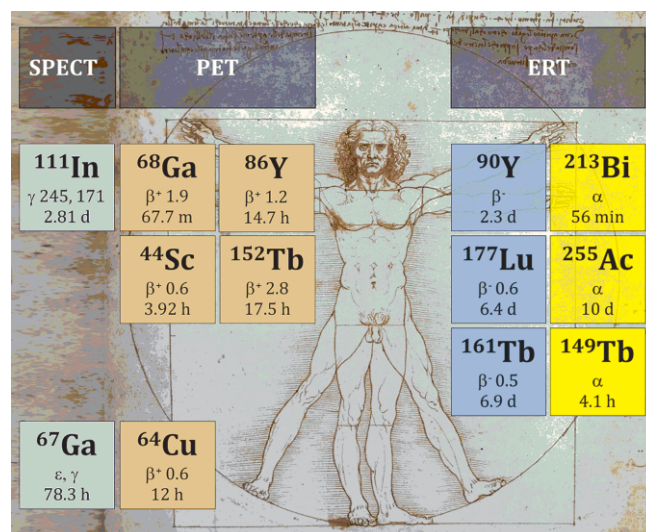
Radionuclides known to work within various DOTA conjugated radiopharmaceuticals allowing for SPECT and PET molecular imaging and for endoradiotherapy.
